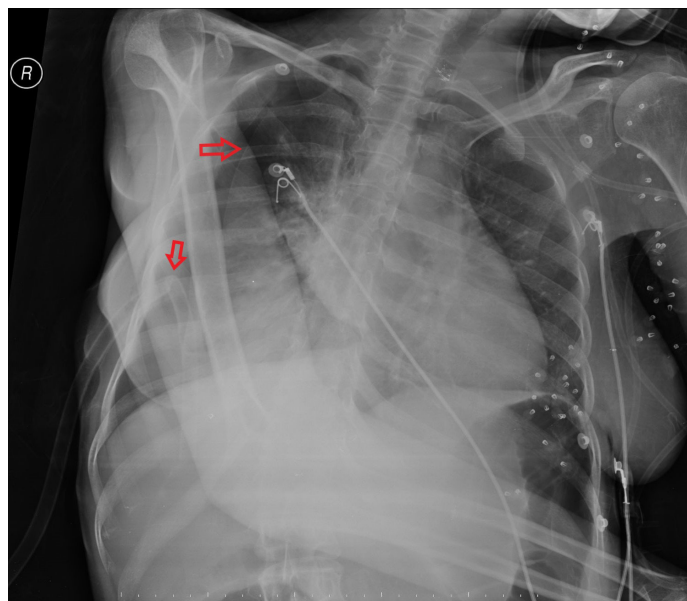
Chest X-ray showing the secondary pneumothorax line resulting from the second placement of the chest tube and the basal malposition of the tube
